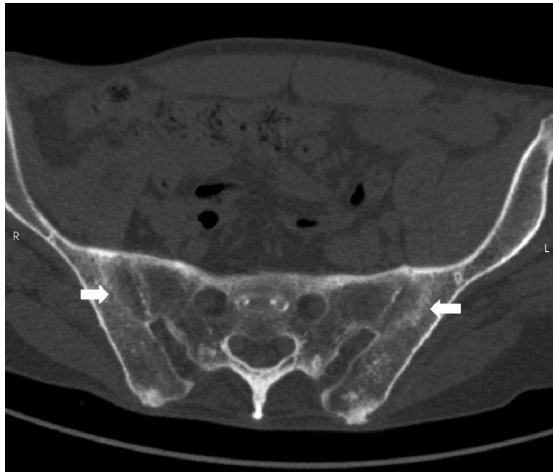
Computed tomography scan of the pelvis revealing bilateral sacroiliitis grade III (arrows).
